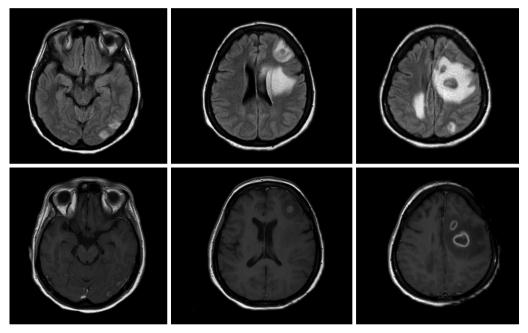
FLAIR-weighted (top) and postcontrast T1-weighted (bottom) images of patient 4 with cerebral toxoplasmosis FLAIR: Fluid-attenuated inversion recovery
